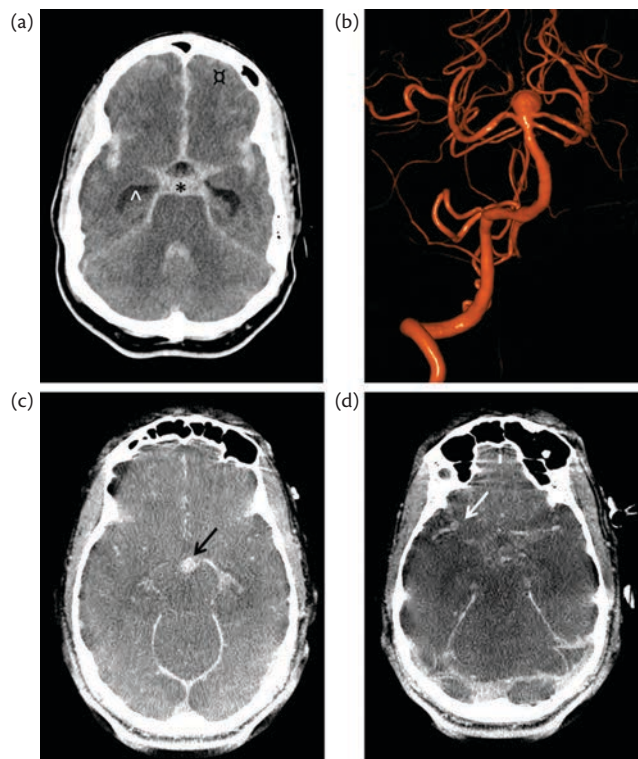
(a) Non-contrast CT head of a patient with ntSAH demonstrating: * hyperdense blood in the subarachnoid space; ^ hydrocephalus in the temporal horns; and α, cerebral oedema. (b) 3D cerebral angiogram of the same patient showing a basilar tip aneurysm. DynaCT of the same patient showing the basilar artery aneurysm (c) and a right middle cerebral artery aneurysm (d).
